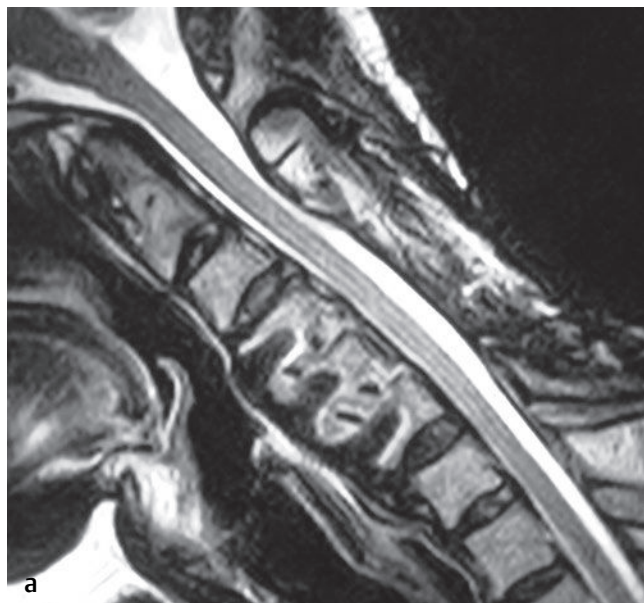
Sagittal T2-weighted images of a patient after C4-C6 anterior cervical decompression and fusion with allograft and plate. (a) Image obtained in flexion on an open, upright MR system shows no substantial stenosis. (b) Image obtained in extension shows moderate stenosis at the C6-C7 level secondary to buckling of the ligamentum flavum (arrow) and disc bulge.[†]
